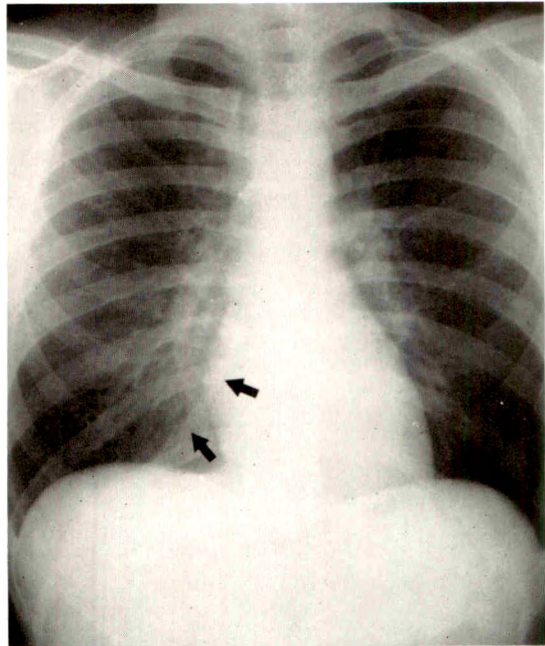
Routine chest roentgenogram showing a ribbon-like shadow on the right extending from the mid-dorsal spine to the right hemidiaphragm.
